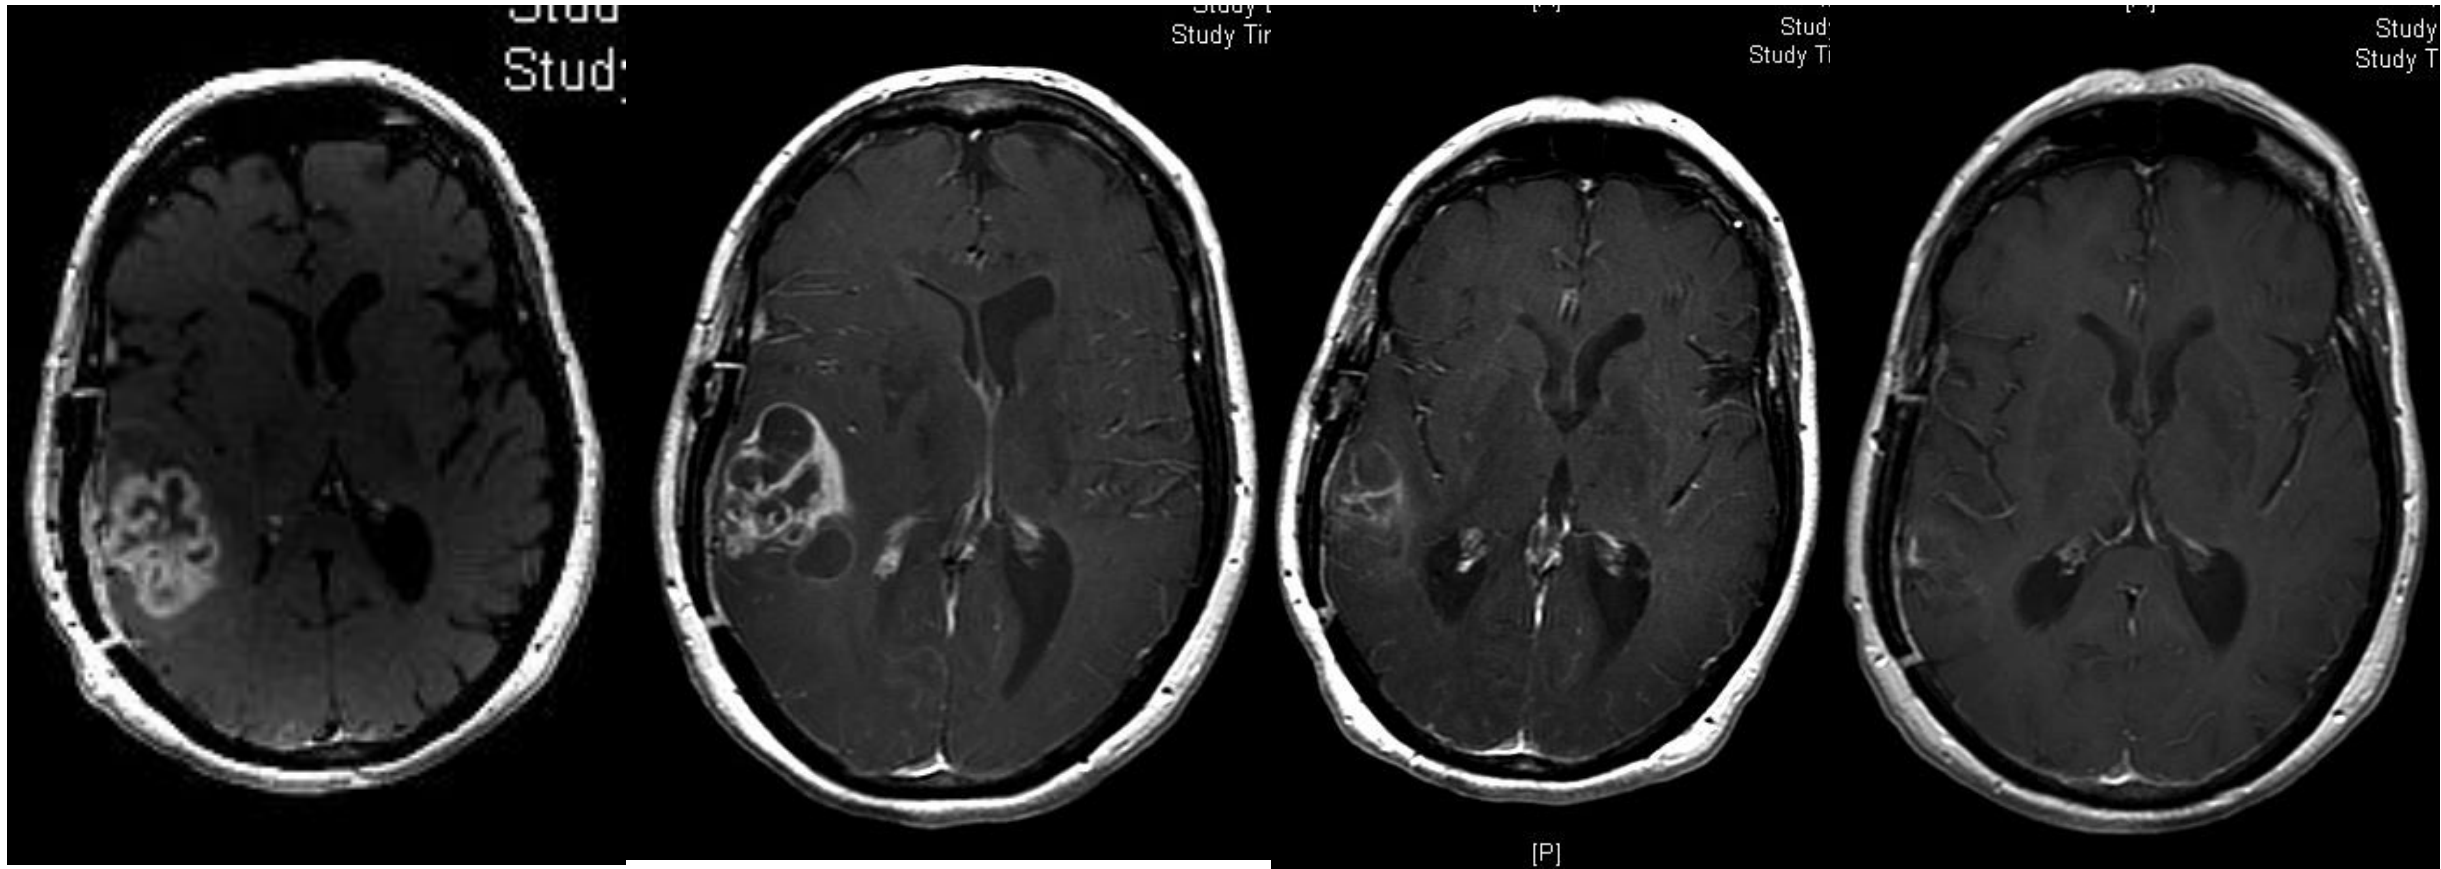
MRI findings, outcomes and MGMT status of patients. MRI, magnetic resonance imaging; PD, disease progression; TMZ, temozolomide; psPD, pseudoprogession; ePD, early disease progression; MGMT, O⁶-methylguanine-DNA methyltransferase.
